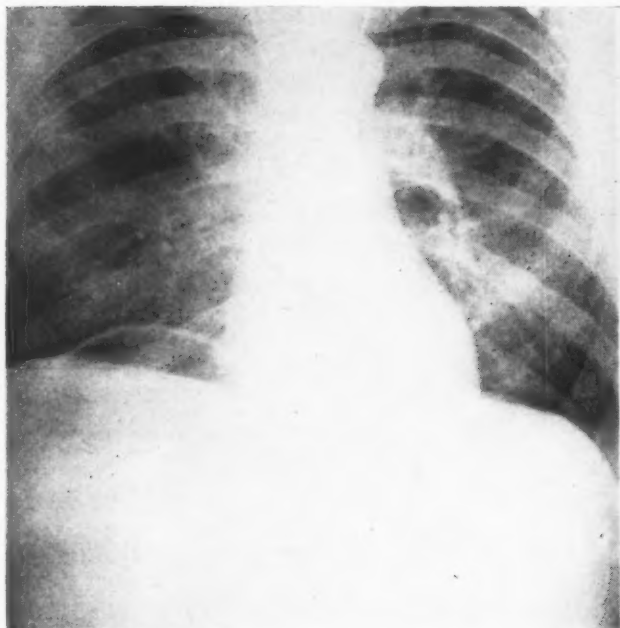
Roentgenogram taken on January 17, 1946, shows the large cyst-like cavity containing fluid and air.
